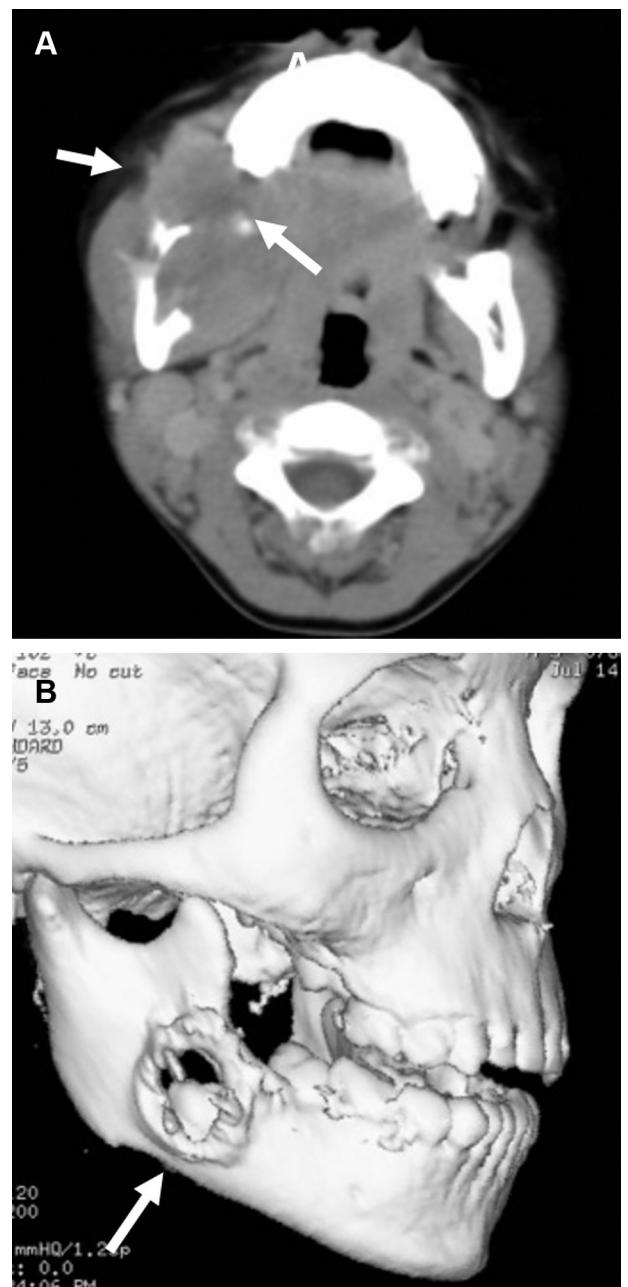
Axial (A) and 3-dimensional (B) CT images. Osteolytic changes and a mass measuring about 4 cm in diameter are found in the right side of the mandible (arrows).
